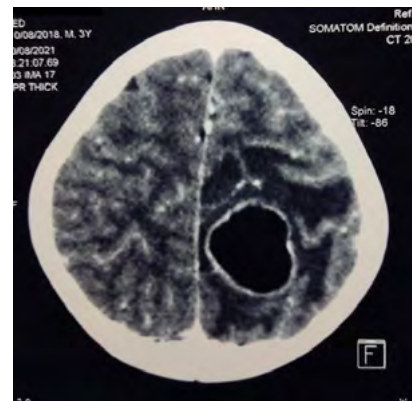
Axial section of a cranioencephalic CT scan with contrast injection revealing the lesion with significant perilesional edema.
